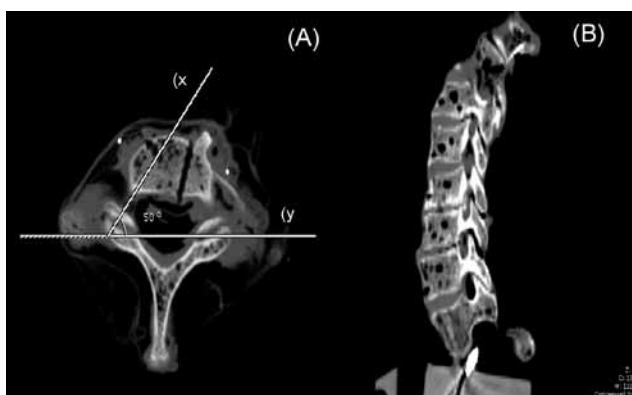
Axial (A) and sagittal (B) computed tomography reconstructions angled 50° with respect to coronal plane (y-axis).
